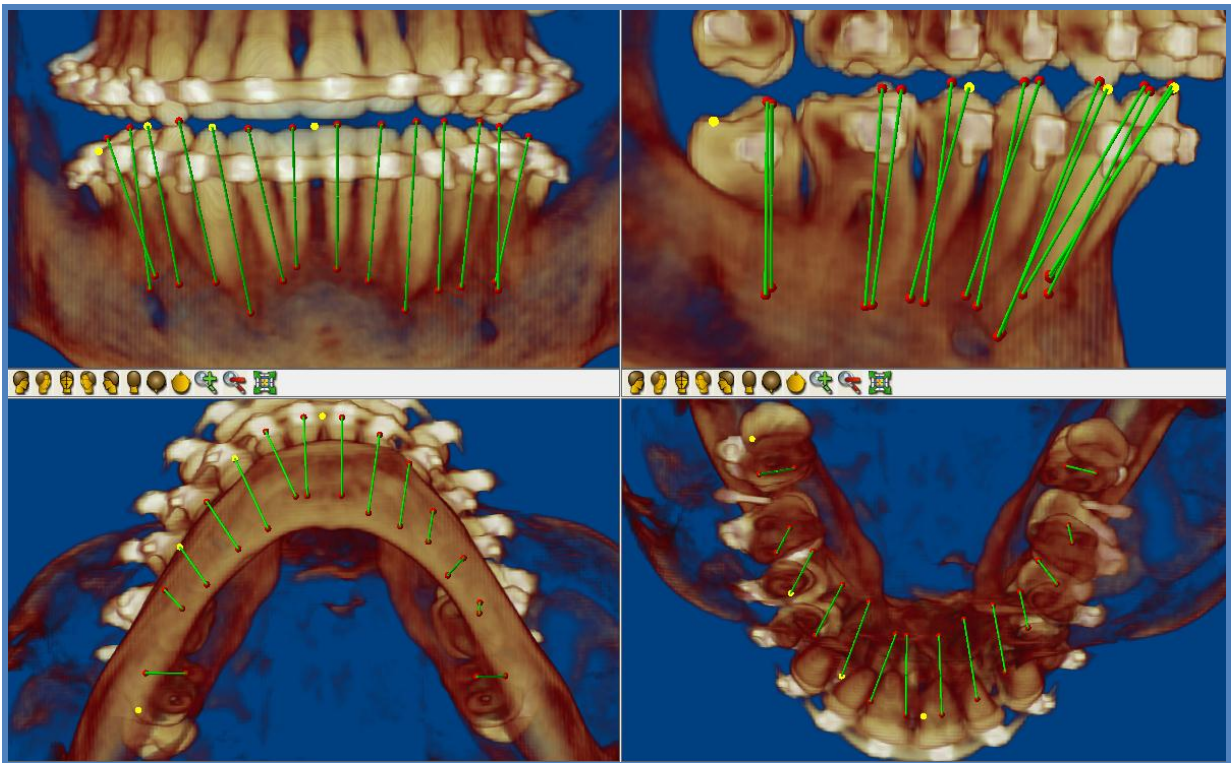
Example of 3D CBCT marker points and angles, after rater placement.
